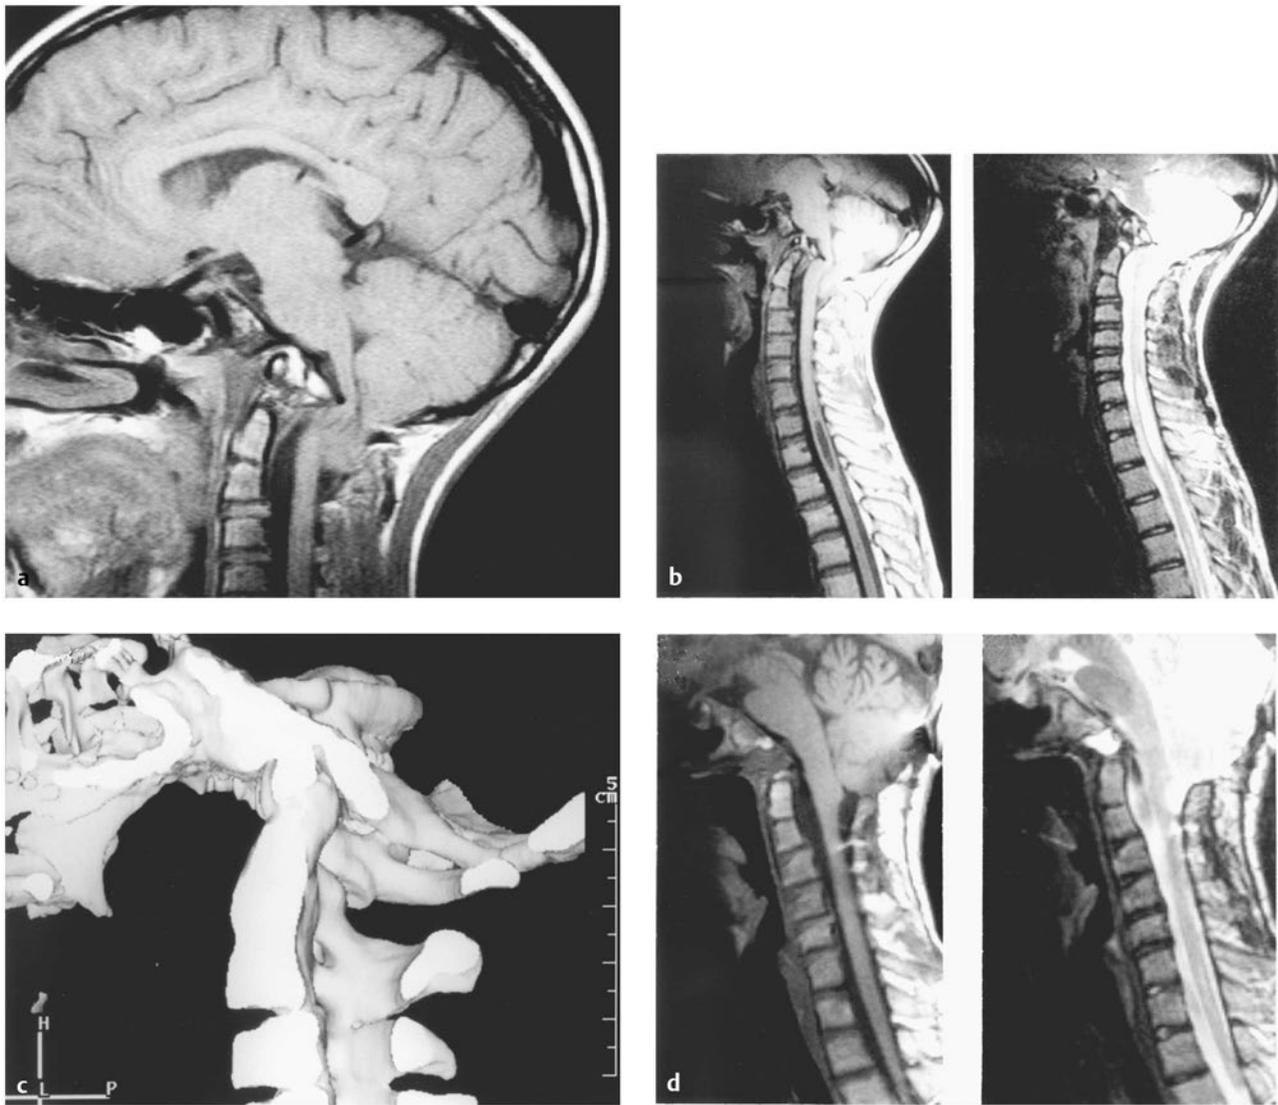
(a) Lateral magnetic resonance (MR) imaging in T1 mode in a 12-year-old girl with palsies of cranial nerves IX, X, and XII bilaterally. There is a ventral indentation into the inferior medulla by a bony mass proceeding from the inferior clivus. A hindbrain herniation is visualized. (b) MR imaging in T1 (left) and T2 (right) mode shows the ventral medullary and basilar artery compression. A hindbrain herniation and a cervicothoracic syrinx are visualized. (c) Three-dimensional computed tomography of the craniocervical junction viewed from within. A proatlantal segmentation defect is seen. A protrusion from the inferior clivus extends into the ventral foramen magnum. There is basilar invagination present and atlas assimilation laterally. (d) Postoperative MR imaging in T1 (left) and T2 (right) mode visualizing the posterior fossa and cervical spine. The patient underwent a transpalatopharyngeal resection of the inferior clivus, proatlantal segmentation bony abnormality, and odontoid process. Note the decompression and absence of the syrinx.
